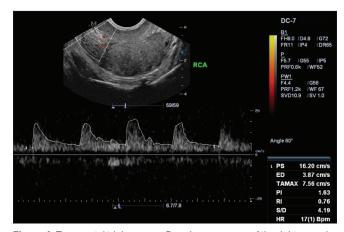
Transrectal triplex power Doppler sonogram of the right capsular artery at the posterolateral aspect of an enlarged prostate gland
